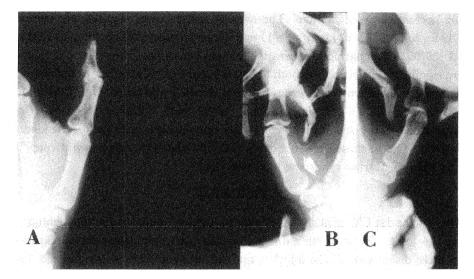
A: Plain lateral view showed no abnormality of the Carpometaphalangeal joint in her left thumb.B: In stress roentgenogram on the A-P view, instability to the radiolateral side compared the opposite side (C:) was
